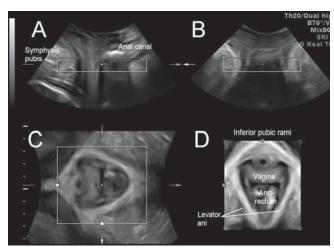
Standard acquisition screen of 3D pelvic floor ultrasound. The midsagittal plane is shown in (A), the coronal plane in (B), the axial plane in (C) and a rendered axial plane (i.e., a semitransparent representation of all pixels in the box seen in A–C) in (D).
